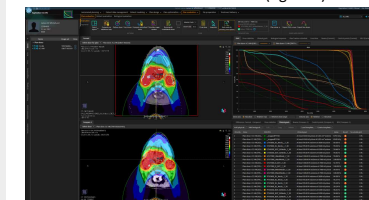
Comparison between adaptive plan on hCBCT (upper left) and on pCT (lower left). Both calculated plans were compared by DVH curves (upper right: CT: solid lines, hCBCT: dash lines) and clinical dosimetric criteria (lower right).
